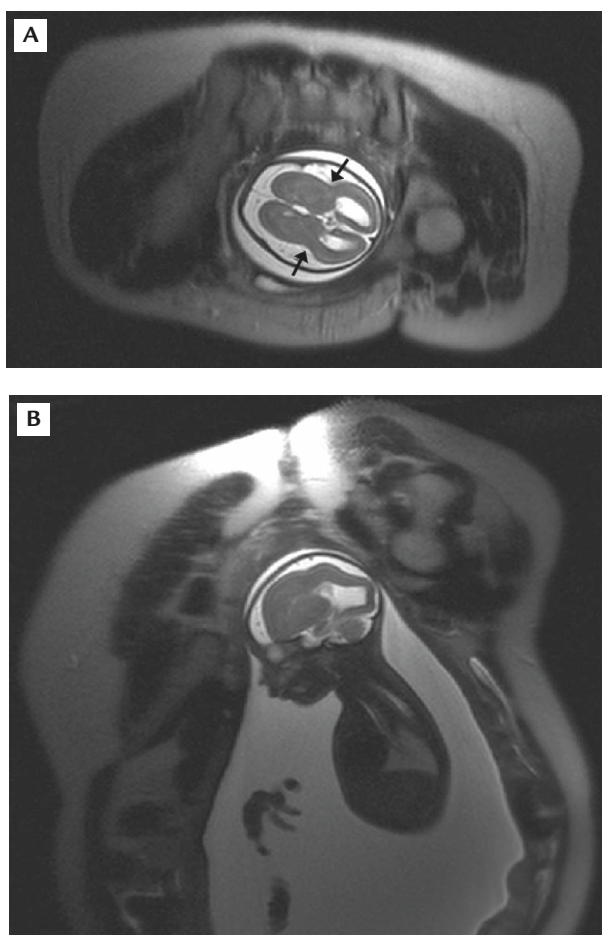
(A, B) Fetal magnetic resonance imaging at 31 weeks' gestation showing agyria/pachygyria, a figure-eight appearance of the brain, wide and shallow Sylvian fissures (arrows), enlarged subarachnoid space, ventriculomegaly, and polyhydramnios.
